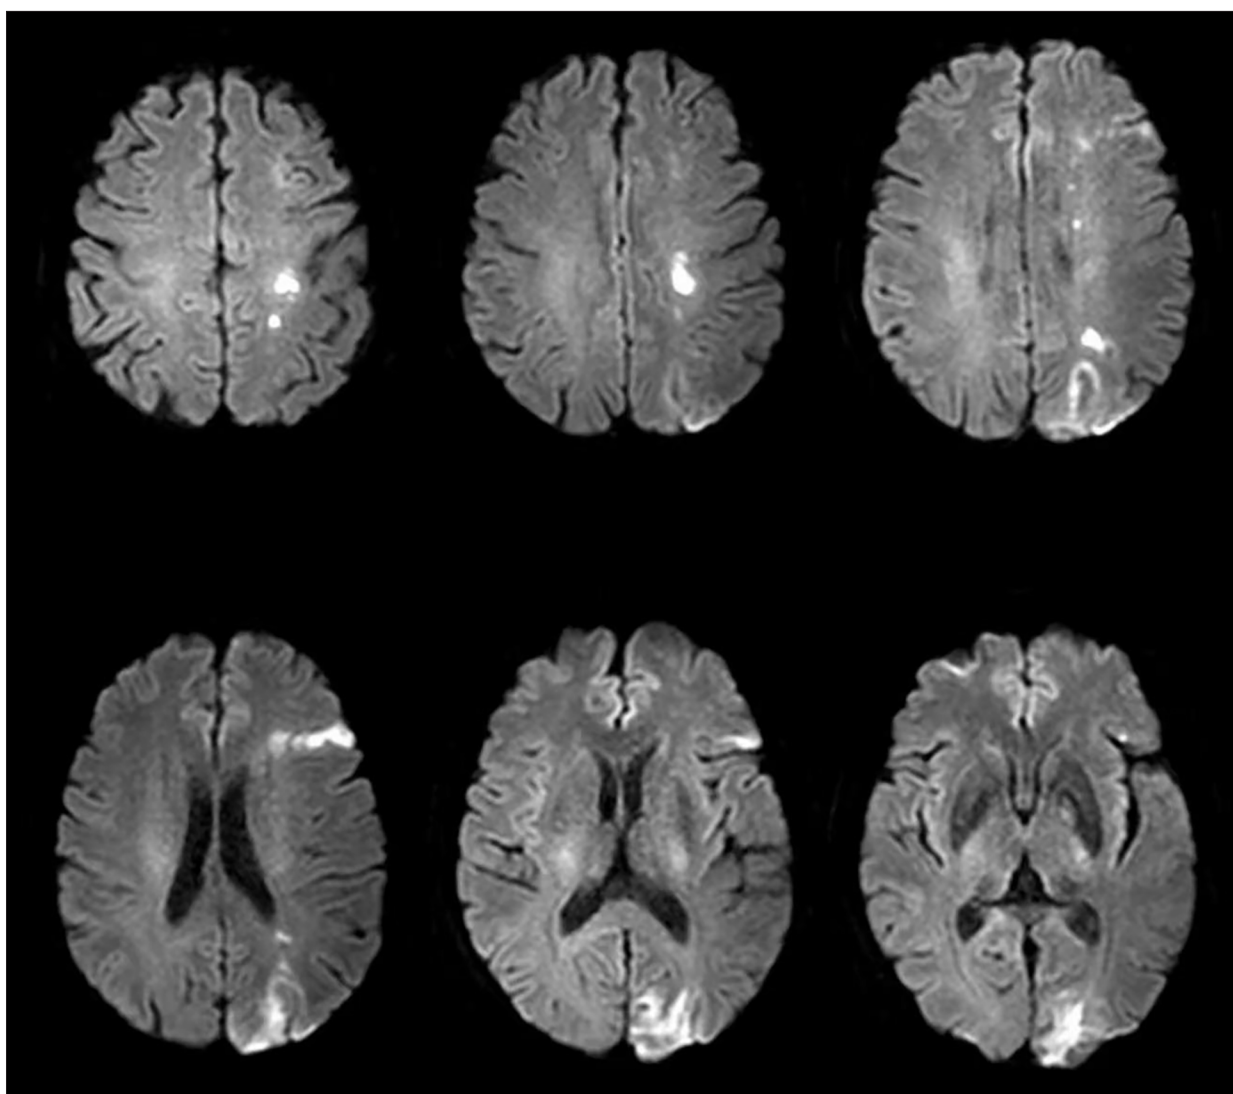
Cranial magnetic resonance imaging demonstrating cerebral atrophy, cerebral white matter hyperintensities (Grade I, modified Fazekas scale), and multiple acute cerebral infarctions involving the left frontal lobe, occipital lobe, and corona radiata.
